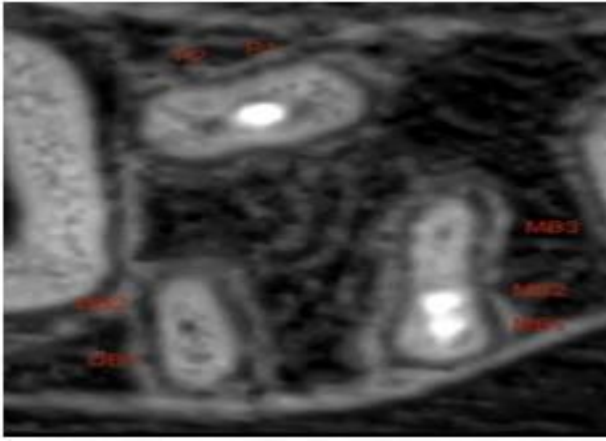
Axial cone-beam computed tomography section.
